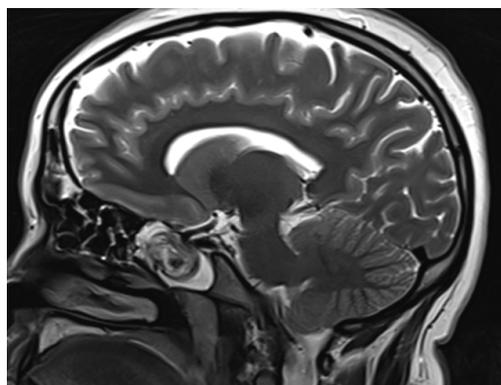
Sagittal T2-weighted MRI showing clear visualization of midline structures, including the corpus callosum and brainstem, with evidence of brain herniation into the right recess of the sphenoid sinus.
